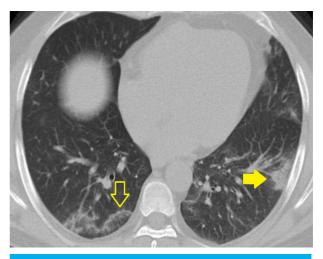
CT chest axial section showing areas of consolidation (solid arrow) and subpleural bands (hollow arrow) with posterior and lower lobar predominance.
